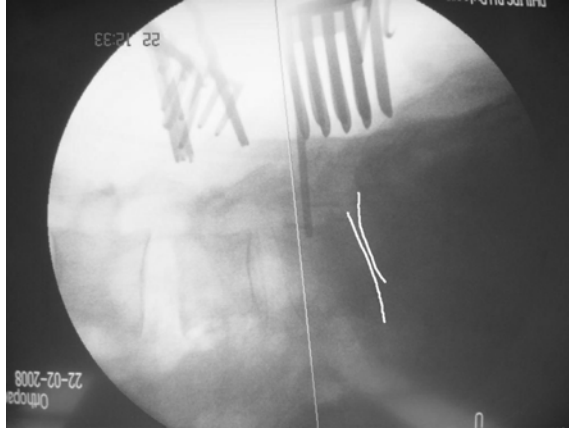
X-ray film shows spondylolisthesis of L5-S1 removing sand bag from KK-MTU
